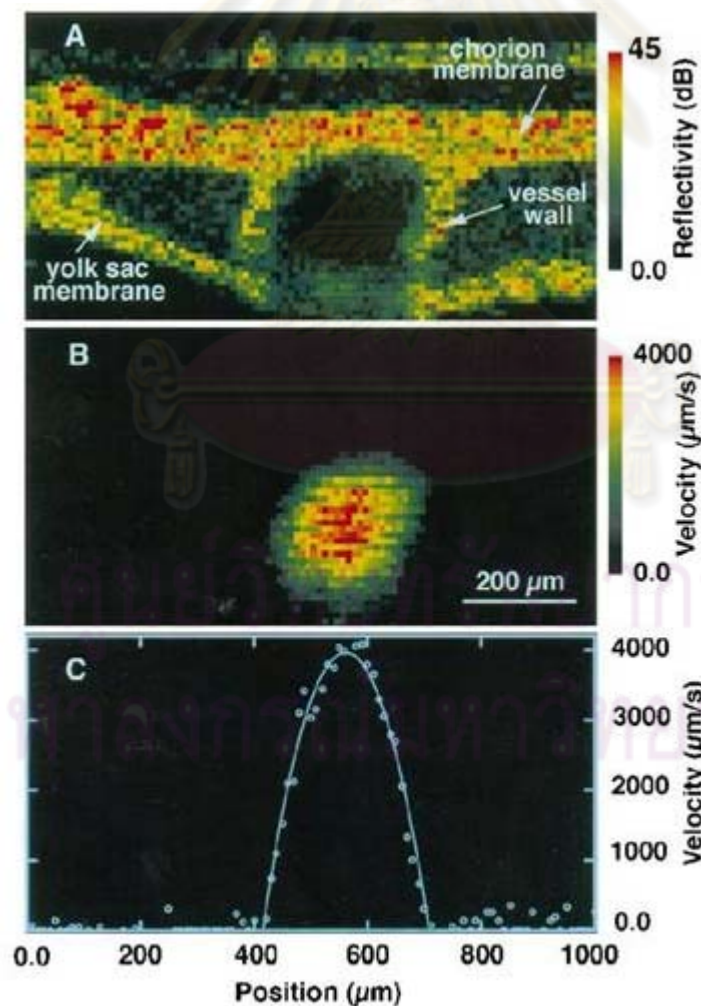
A: Structural image of a chick chorioallantoic membrane (CAM) obtained with optical Doppler tomography [11]. B: Two-dimensional distribution of blood flow velocity in the CAM vein. C: Velocity distribution along the horizontal diameter of the vein shown in Fig. 3B.
